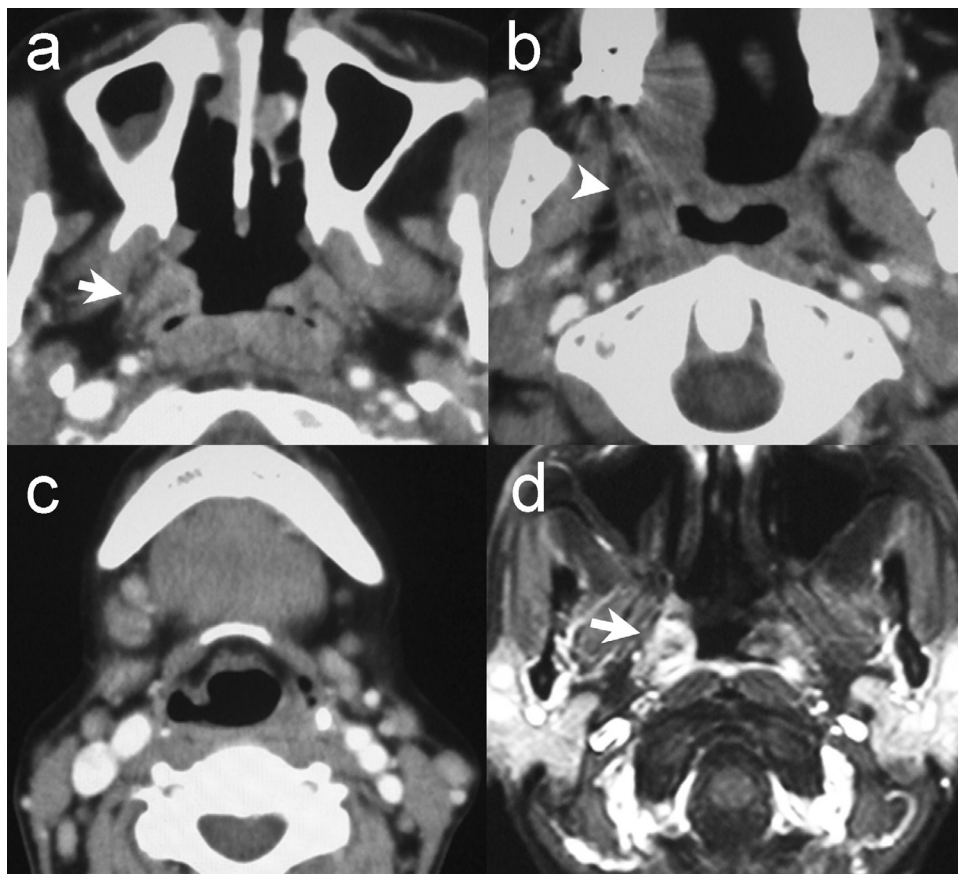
Contrast-enhanced CT scan shows right torus tubarius swelling (arrow) (a) and a low-density area (arrowhead) at the right oropharynx (b). The bilateral cervical lymph nodes are also swollen (contrast-enhanced CT) (c). Enhanced T1-weighted MRI reveals a high-intensity area (arrow) at the right oropharynx (d).
